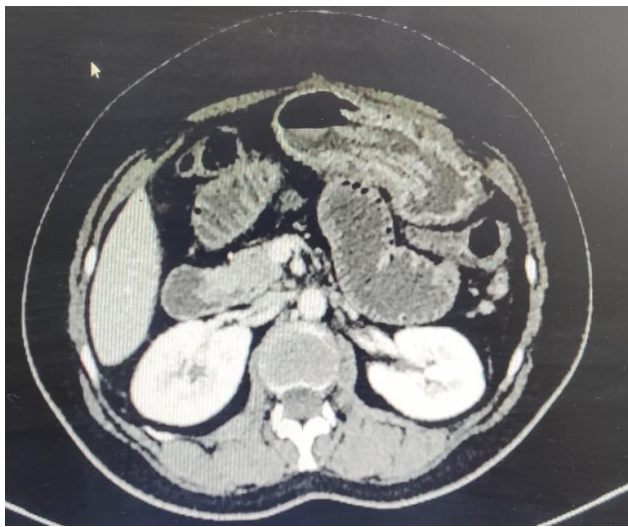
CT abdomen of acute intestinal obstruction
